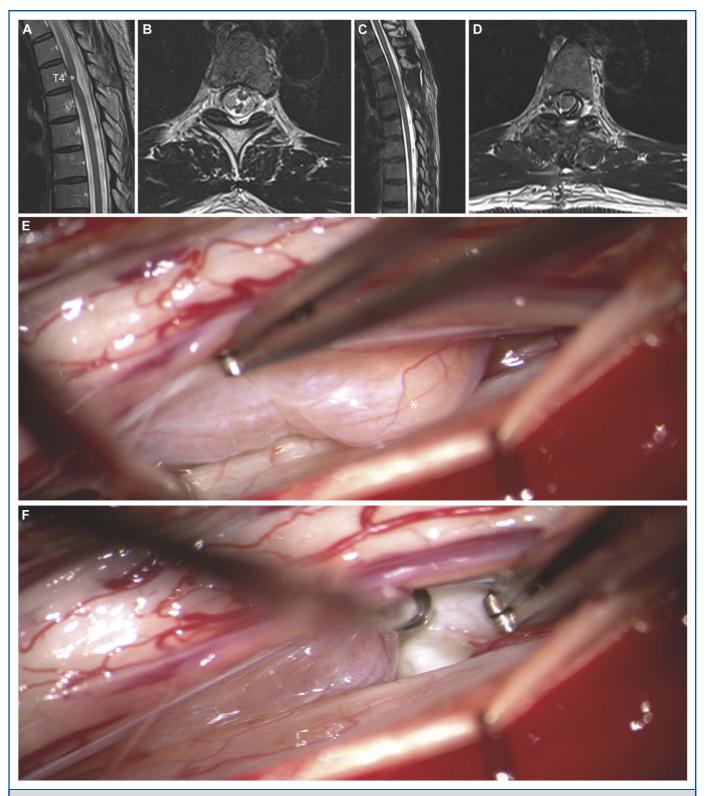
MRI of a 46-year-old female patient who suffered from a spinal cord hernia at T4. A, Sagittal T2-MRI showing the spinal cord herniated at the fourth thoracic vertebrae. B, Corresponding axial T2-MRI. Postoperative sagittal C, and axial D, T2-MRI after surgery showed a released spinal cord without any new attachments. Intraoperative imaging showing the spinal cord hernia through the spinal dura E, before and F, after herniolysis. *Herniated spinal cord.
